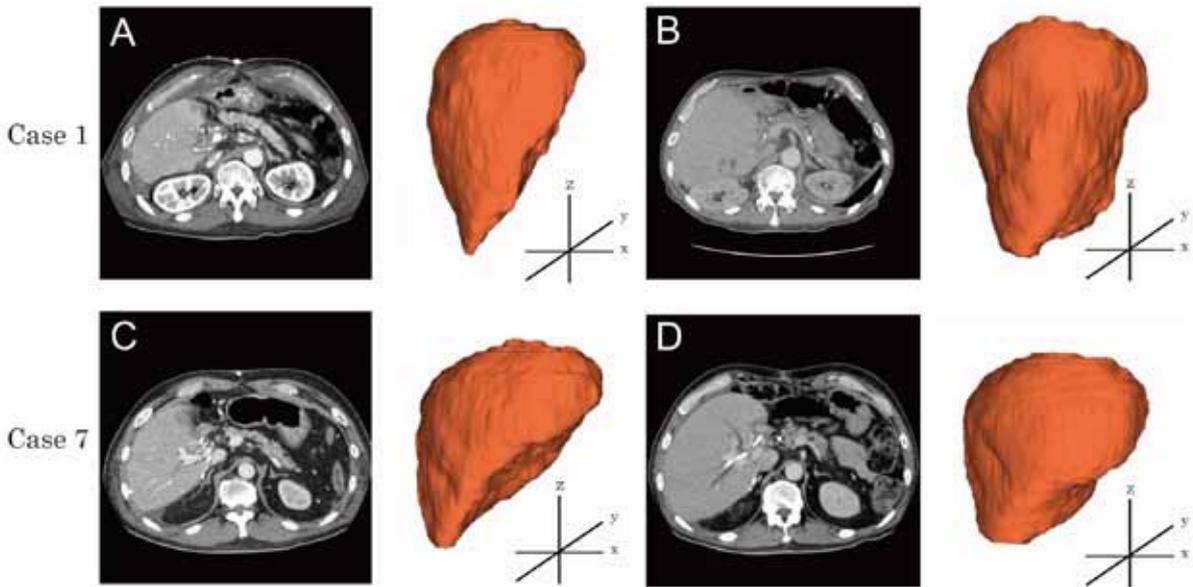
CT and liver volume rendering. (A) Early and (B) late time points of Case 1; (C) early and (D) late time-points of Case 7. The left and right panel in each box indicate the CT and volume rendering of the regenerating liver, respectively.
